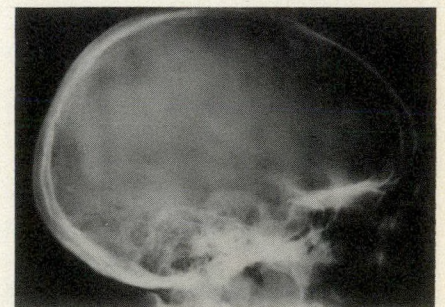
Lateral skull x-ray film showing displaced fracture of floor of sella turcica (type II) with air fluid level in sphenoid sinus.
